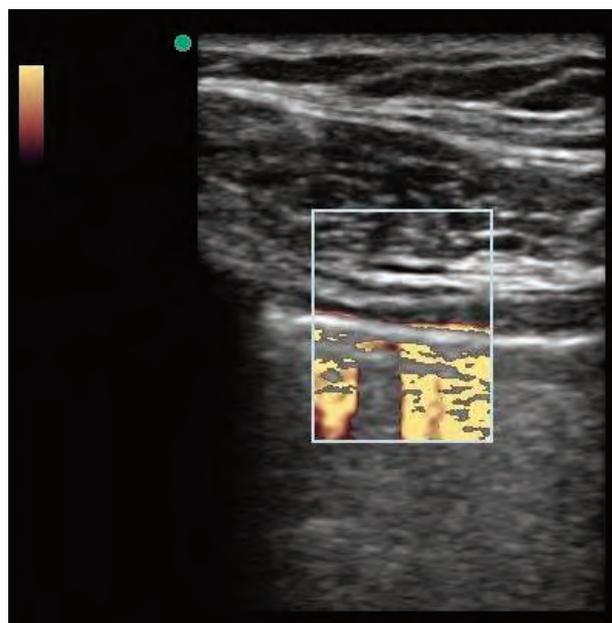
Power Doppler visualisation of a normal lung
